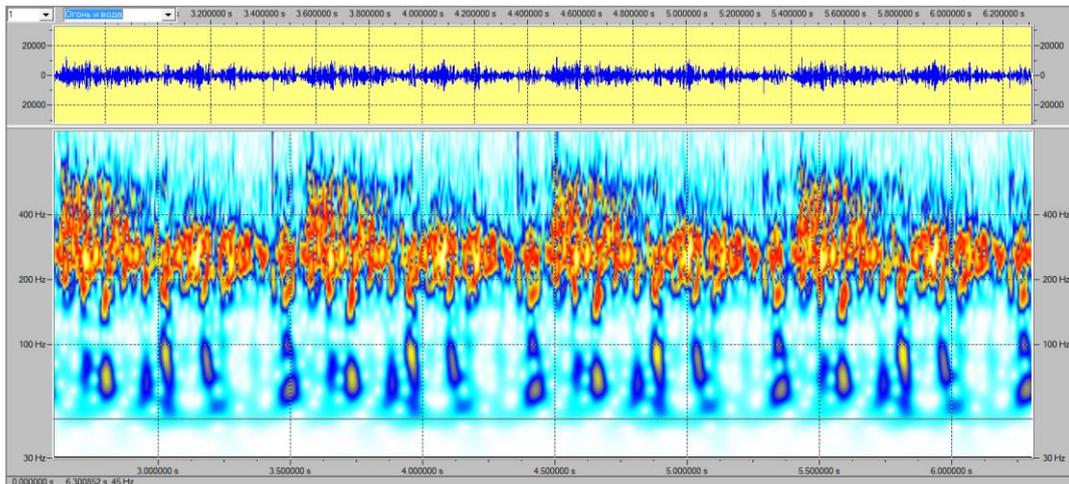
Acoustic sonogram of the sound of puerile breathing of an infant
